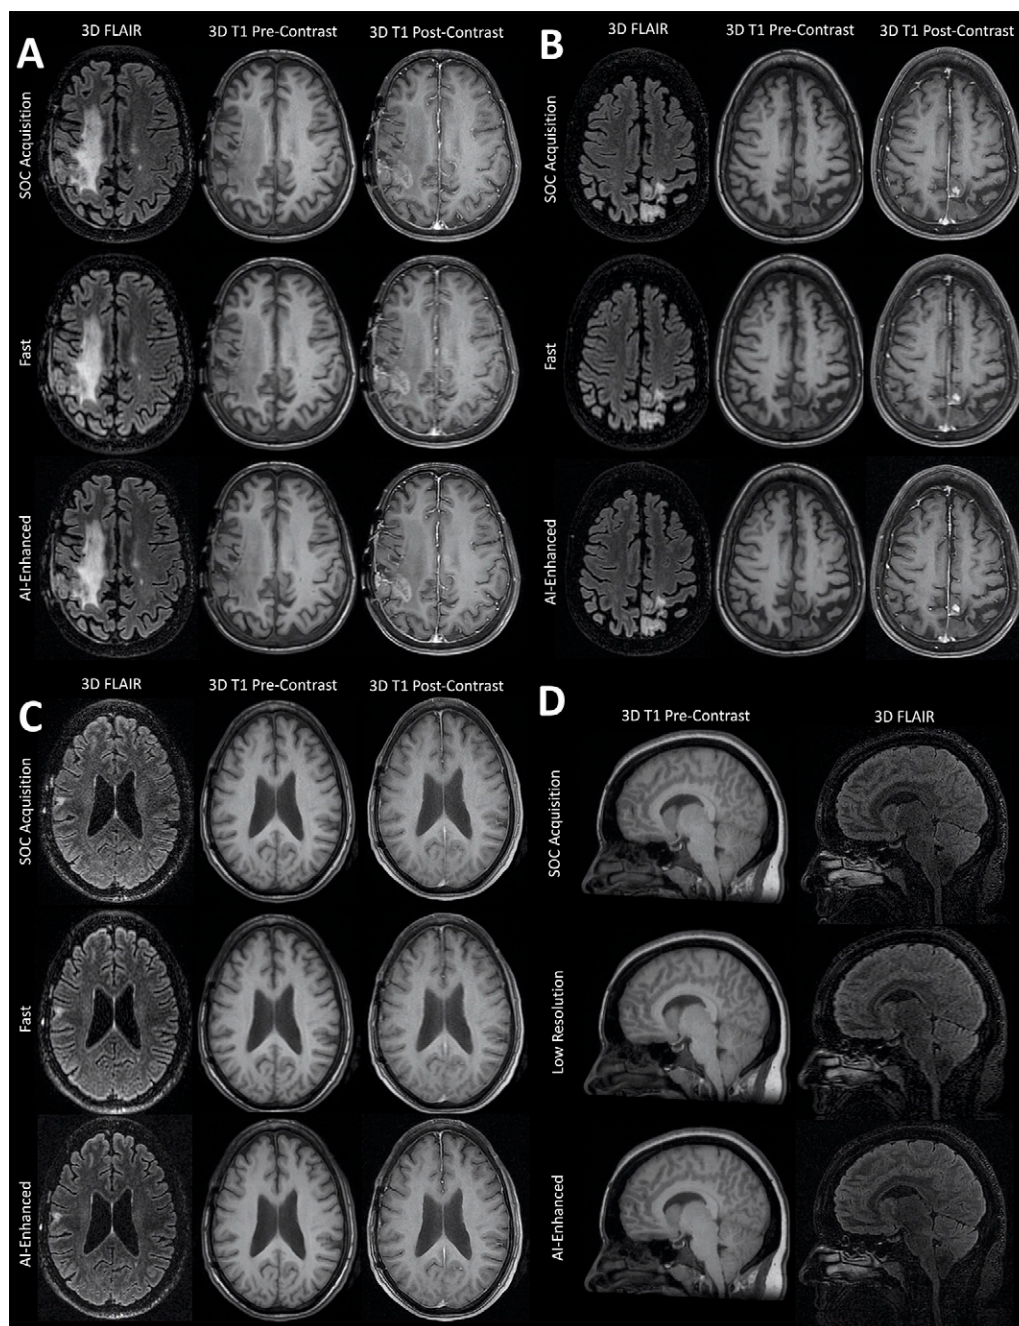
Example clinical MRI studies. (A–C) Three example axial three-dimensional (3D) fluid-attenuated inversion recovery (FLAIR) (first column), 3D T1 precontrast (second column), and 3D T1 postcontrast (third column) images from standard-of-care (SOC) acquisition (first row), low-resolution fast-acquisition (second row), and artificial intelligence (AI)-enhanced (third row) images in three patients being evaluated for follow-up of diffuse gliomas. (D) Example sagittal 3D T1 precontrast (first column) 3D FLAIR (second column), SOC acquisition (first row), low-resolution fast-acquisition (second row), and AI-enhanced (third row) images in a patient with headaches, determined to have intracranial hypotension.
